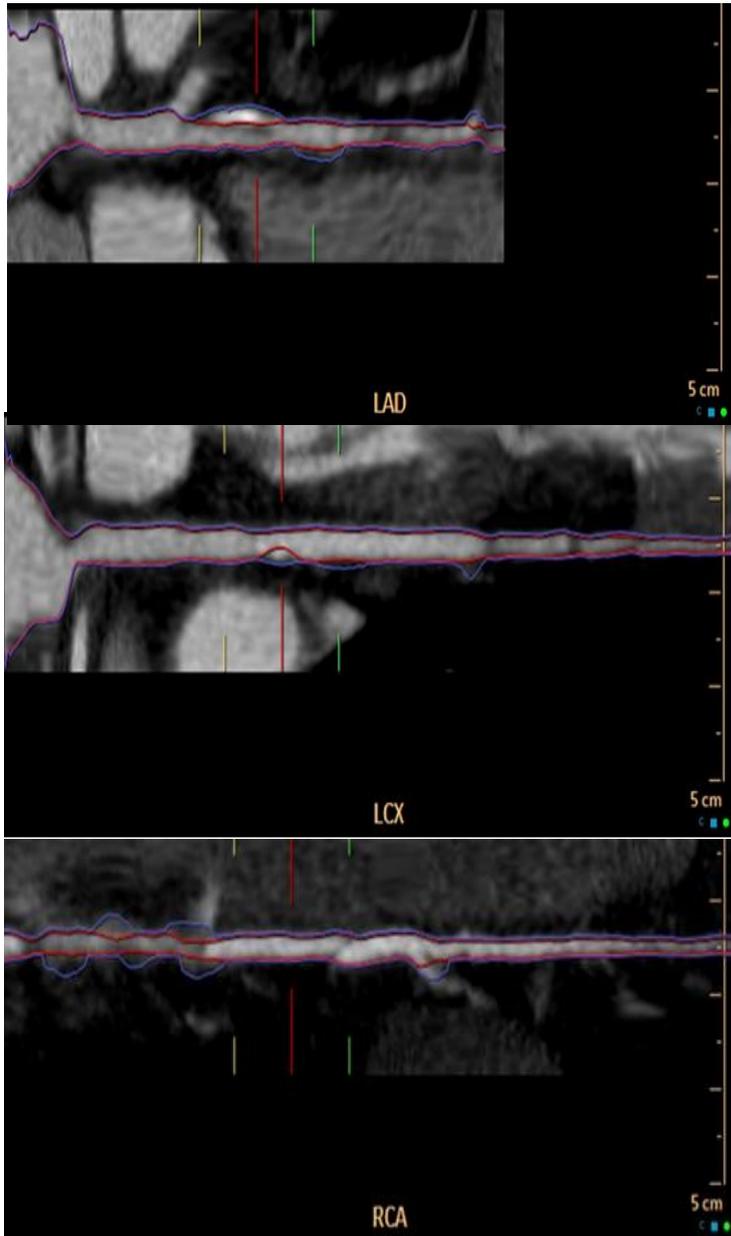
CT coronary angiography of LAD, LCX and RCA images, together with use of multiplanar reconstruction to quantify plaque volume in each vessel. This 66 year old woman with a positive FHx had CCS 65 with plaque volume of 54mm³.
